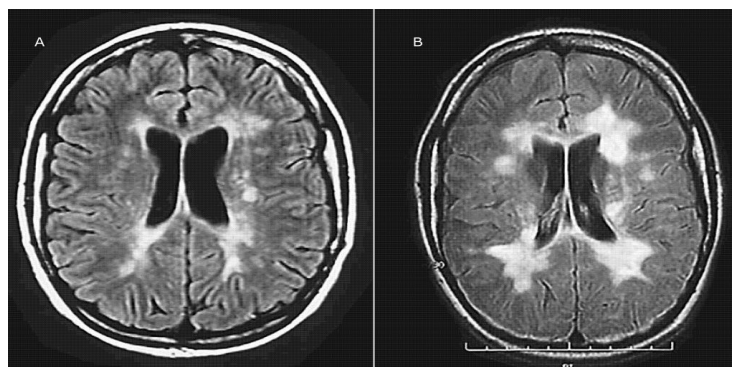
MRI scans of the brain of a 25-year-old woman with relapsing-remitting MS (A) and nine months later (B) .
